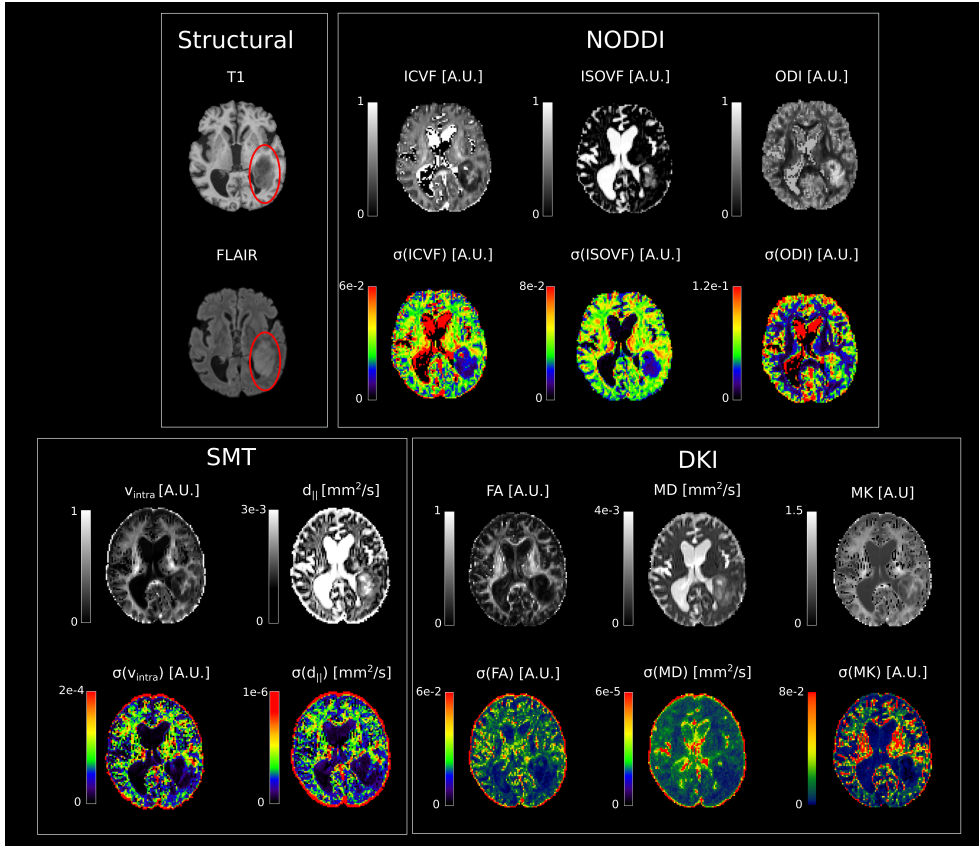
An axial slice from a representative patient showing its T1w and FLAIR structural images as well as both NODDI/SMT/DKI metrics (first row of each box, grey scale) along with their standard deviation map (second row, jet scale). NODDI = neurite orientation dispersion and density imaging, SMT = spherical mean technique, DKI = diffusion kurtosis imaging, ICVF = intracellular volume fraction, ISOVF = isotropic volume fraction, ODI = orientation dispersion index, FA = fractional anisotropy, MD = mean diffusivity, MK = mean kurtosis.
